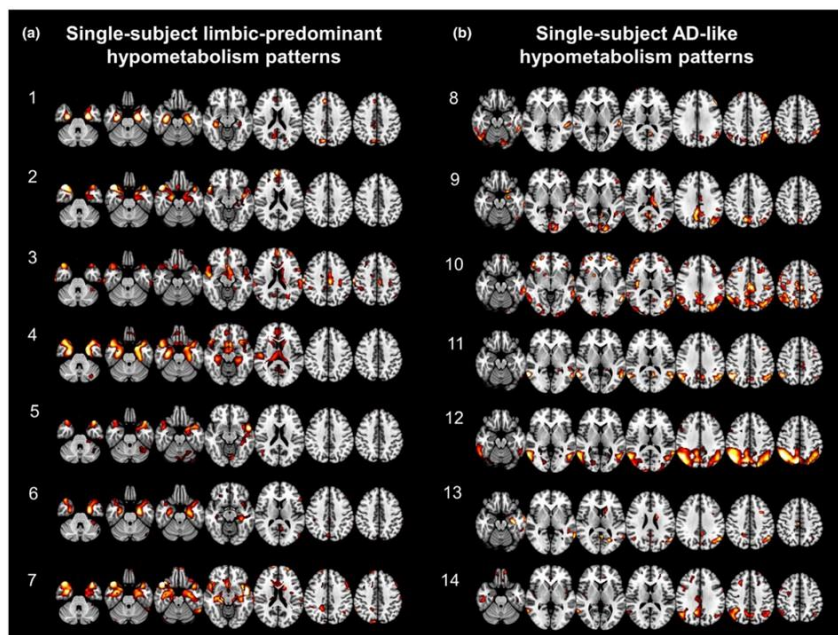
Examples of single-subject [¹⁸F]FDG-PET hypometabolic patterns (source: Tondo *et al.*, 2020a).
